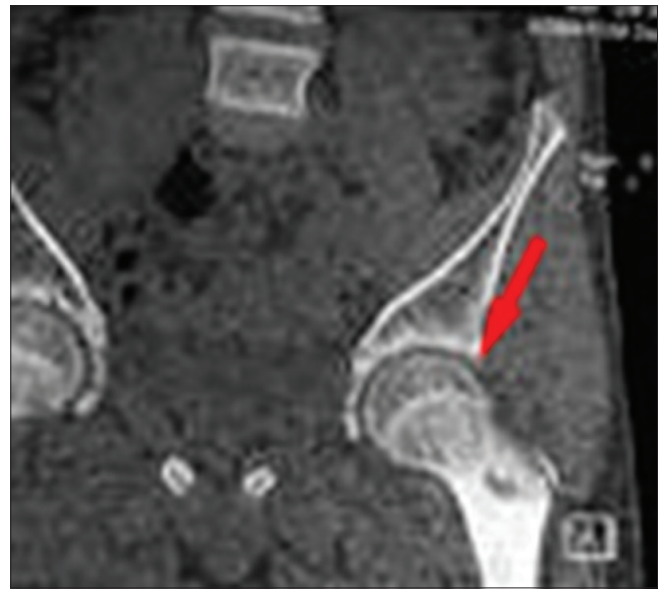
Computed tomography scan (sagittal cut) showing nidus at inferomedial aspect of femoral neck measuring around 9 mm suggestive of osteoid osteoma (Red arrow)
